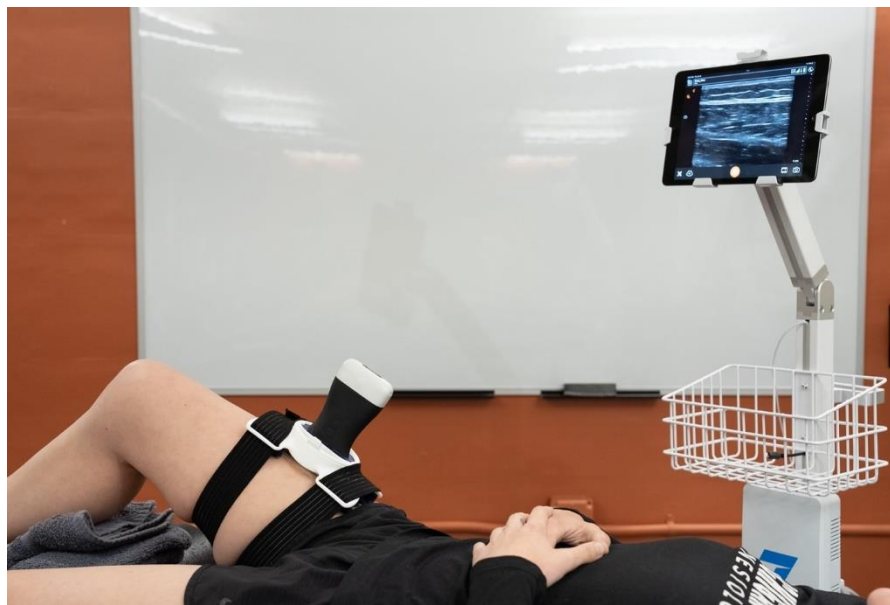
Wireless ultrasound placement for dynamic ultrasound assessment. The wireless Clarius ultrasound was attached at the 50% of the vastus lateralis with the Usono mounting strap with the participants were supine on the examination table. The probe was placed on the longitudinal plane.
